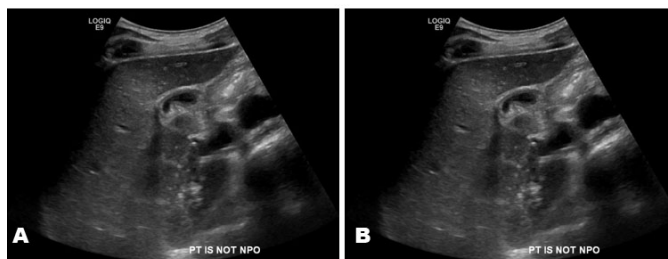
(A) Right upper quadrant ultrasound—Transverse view of the gallbladder—The gallbladder appears normal. No stones are identified. No biliary ductal dilatation or gallbladder wall thickening is present. (B) Right upper quadrant ultrasound—Longitudinal view of the gallbladder—The gallbladder appears normal. No stones are identified. No biliary ductal dilatation or gallbladder wall thickening is present.
